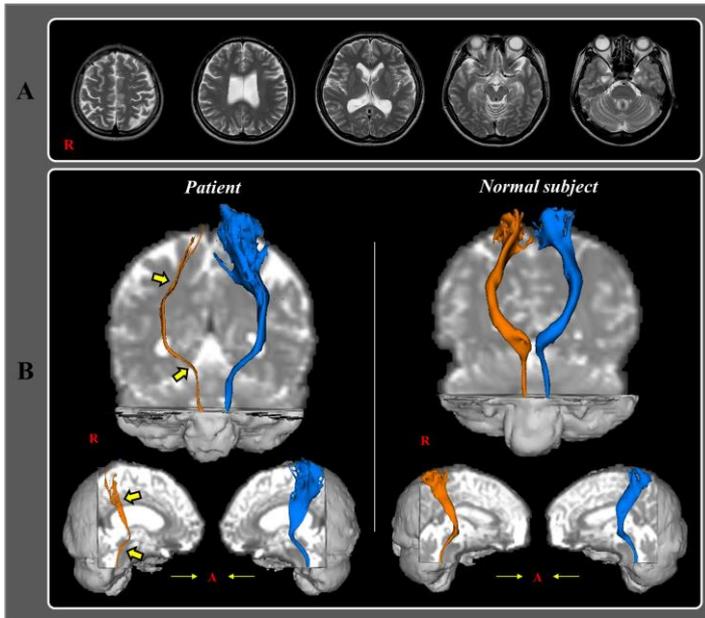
(A) Brain magnetic resonance images obtained seven days after head trauma onset show no definite lesions. (B) Results of diffusion tensor tractography performed 7 days after onset. The right spinothalamic tract shows severe narrowing and partial tearing in the subcortical white matter (yellow arrow) compared with those of the patient's left side and those of a normal subject (38-year-old female).
